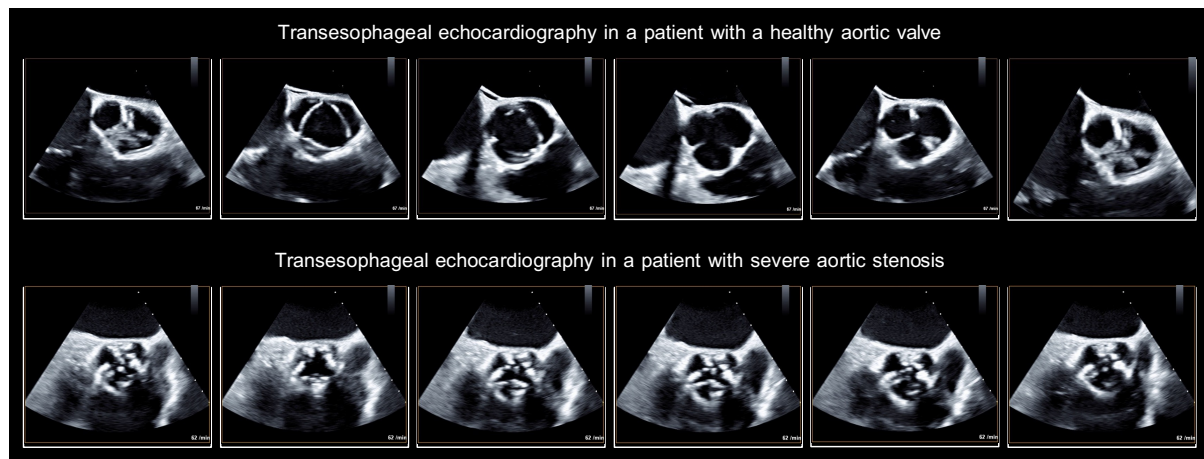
Planimetry of the aortic valve area by transesophageal echocardiography.
